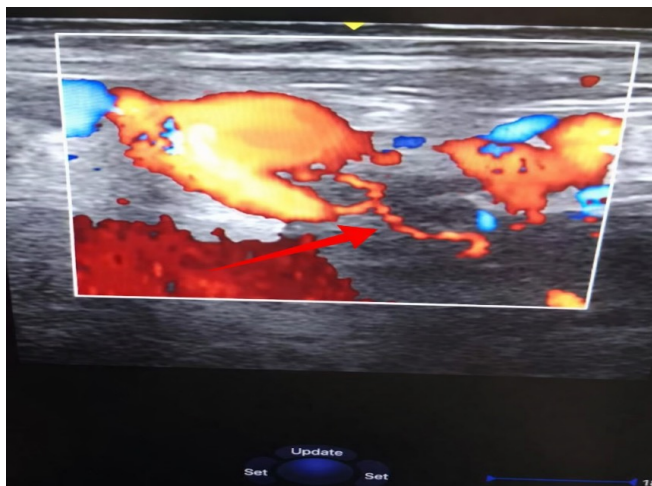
Doppler ultrasound showing the portal vein with a serpiginous appearance indicative of a portal cavernoma.
